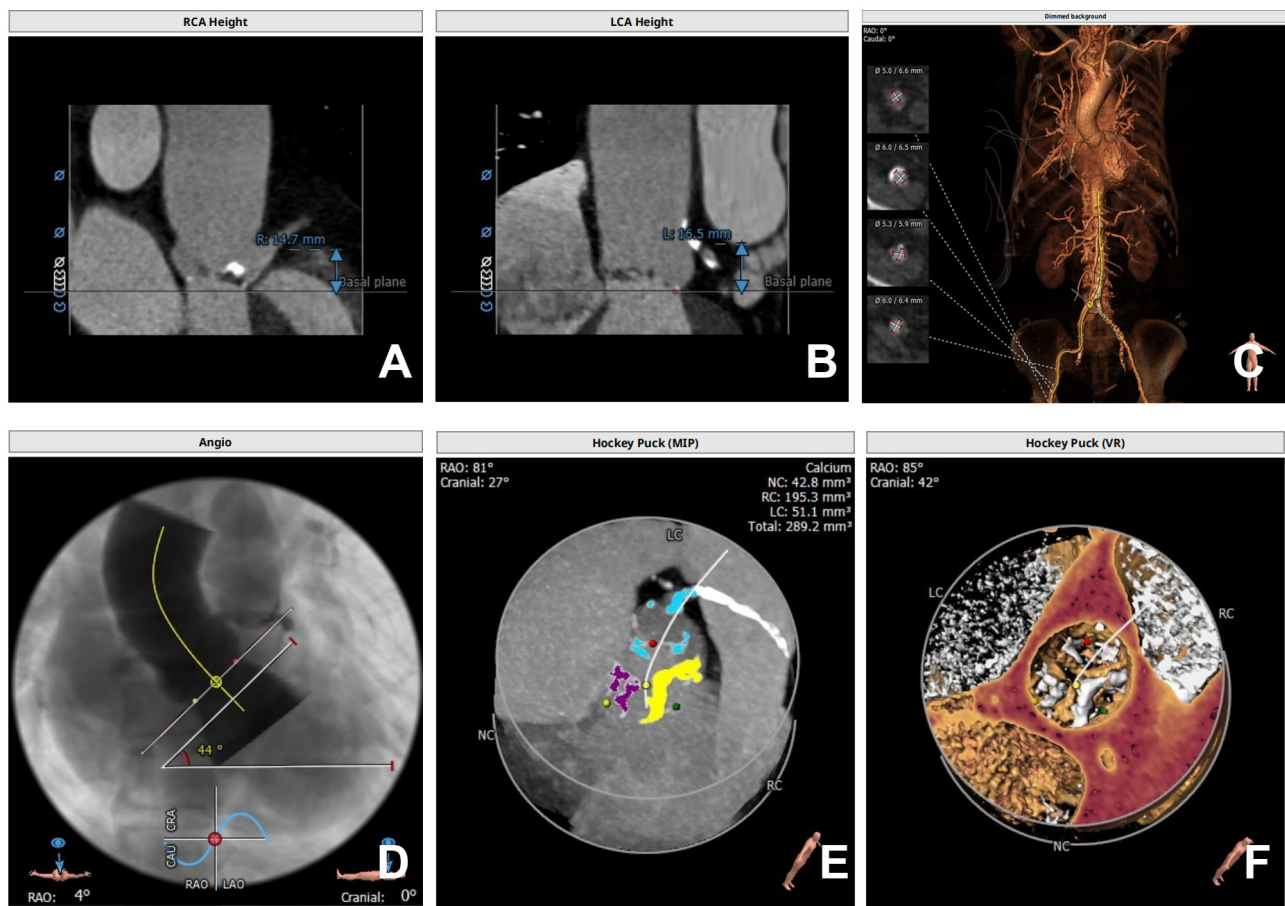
Pre-TAVR aortic CTA imaging assessment. (A) The height of the right coronary artery ostium measured 14.7 mm. (B) The height of the left coronary artery ostium measured 16.5 mm. (C) The right femoral artery was selected as the primary access site. (D) The aortic root angulation was 44 degrees. (E,F) The aortic valve shows thickening with associated calcification.
